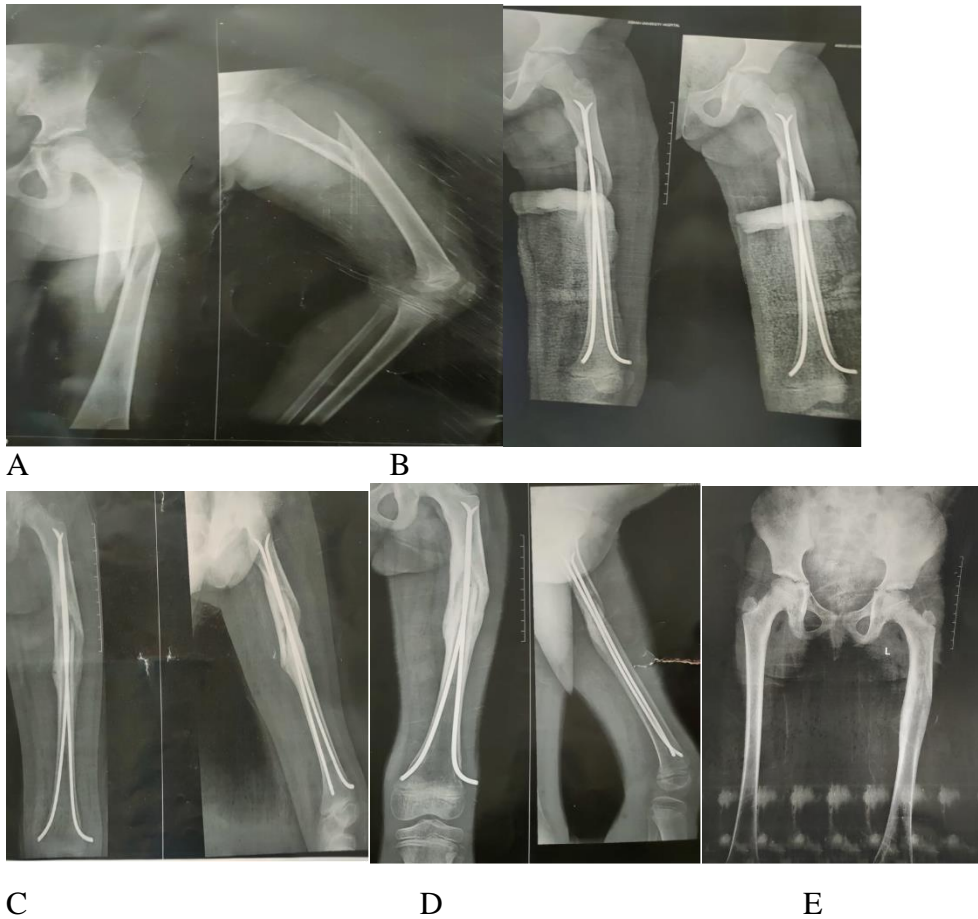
case 1, Patient profile: Female child, 7 Years old, with fracture of left side femur. A) Antero-posterior and lateral X-rays of the right femur showed a long oblique fracture with a medial butterfly at the junction between the proximal third and the midshaft of the femur. B) Immediate postoperative x-ray AP and Lateral views showed fixation with 2 ESIN. C) 6 weeks postoperative X-ray AP and Lateral views showed fracture callus consolidation, D) 3 months post operative X-ray AP and Lateral views showing complete fracture healing. E) 9 months post operative X-ray AP and Lateral views showed complete fracture healing and removal of the nails
